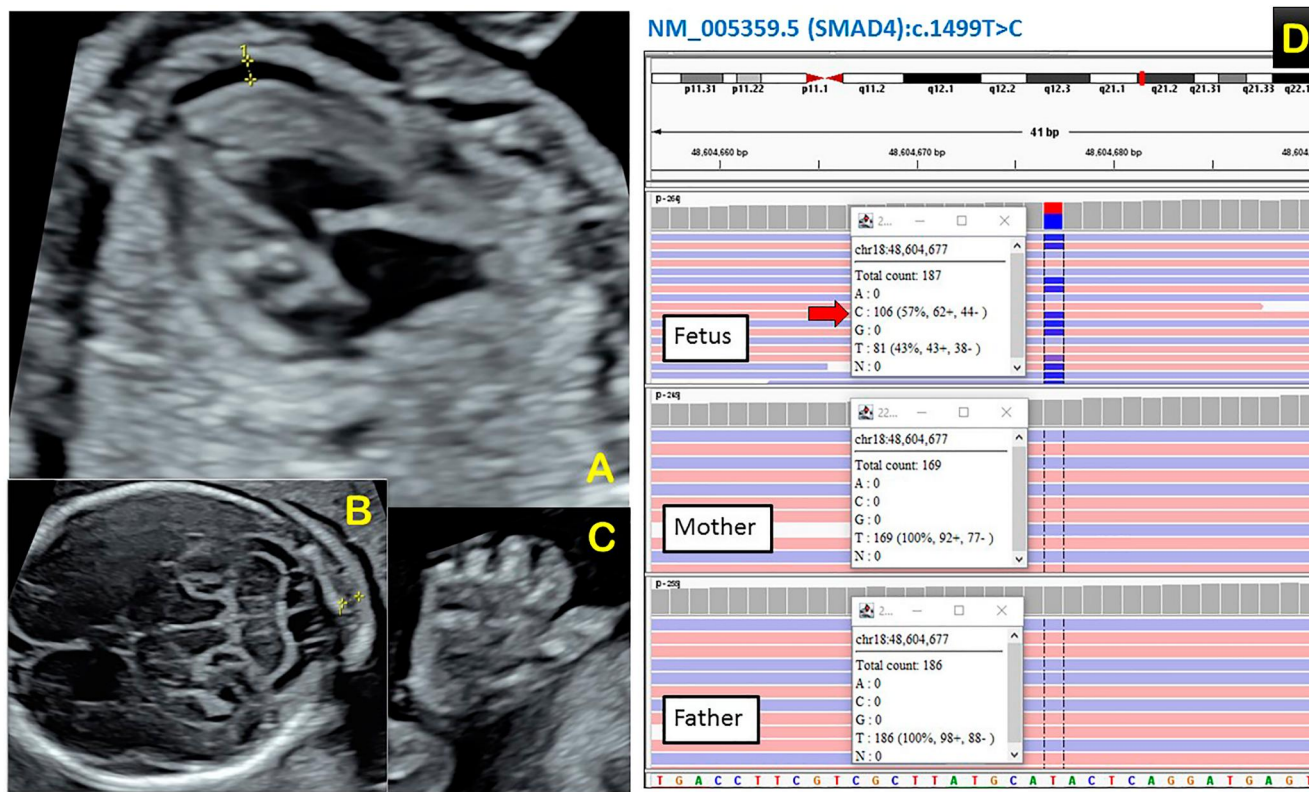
Prenatal ultrasound at 19 weeks of gestation showing thickened pericardium and pericardial effusion (1.2 mm) reflecting possible underlying cardiomyopathy (A). There was persistently increased nuchal fold and brachydactyly (B&C). Integrative genomics viewer demonstrating a de novo heterozygous variant NM\_005359.5(SMAD4): c.1499T>C (p.Ile500Thr) detected by Whole exome sequencing (WES) representing Myhre syndrome (D).
